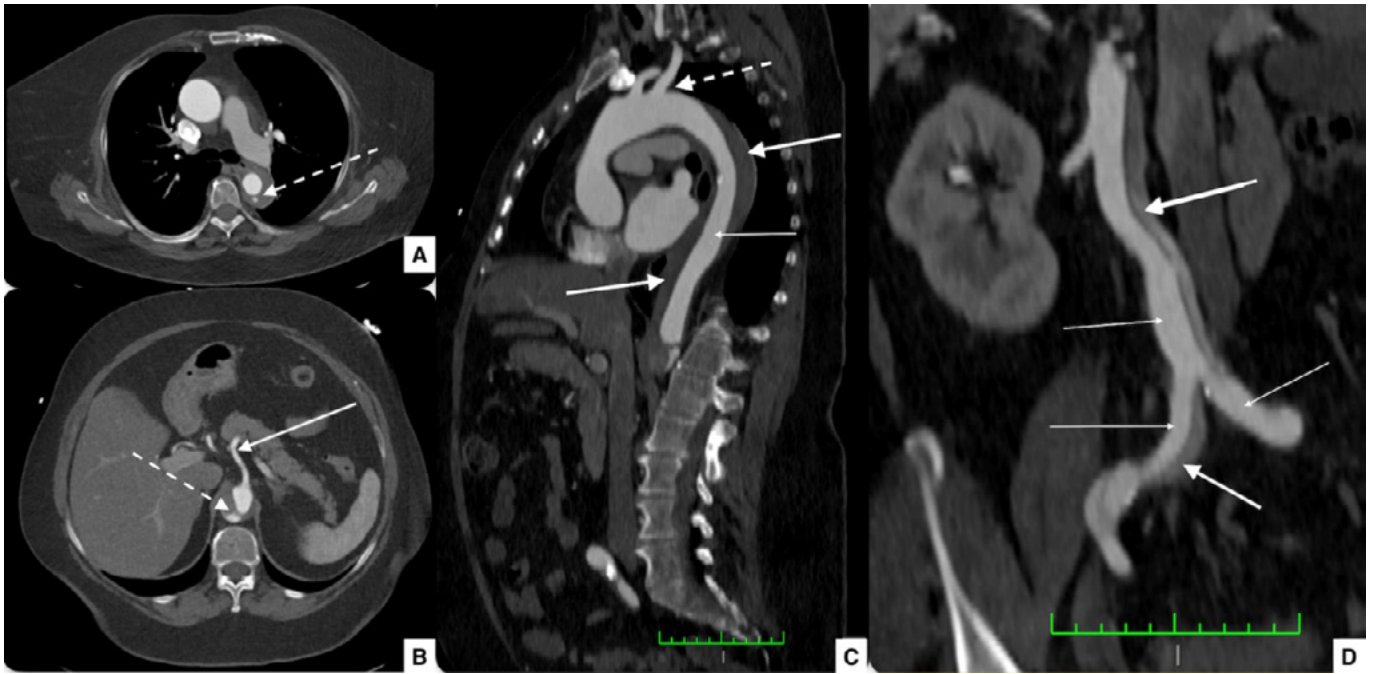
Pre-operative CTA. A: Axial image indicating proximal entry tear (dashed arrow) and intramural hematoma. B: Axial image indicating a second entry tear (dashed arrow) at the level of the celiac artery origin (solid arrow). C: Sagittal image indicating the false lumen and intramural hematoma (thick white arrows), the true lumen (thin white arrow) and the level of the primary first entry tear (dashed arrow), just distal to the origin of LSCA. D: Coronal views of the aorta (thick arrow indicating the false lumen/intramural hematoma, thin arrows indicating the true lumen).
